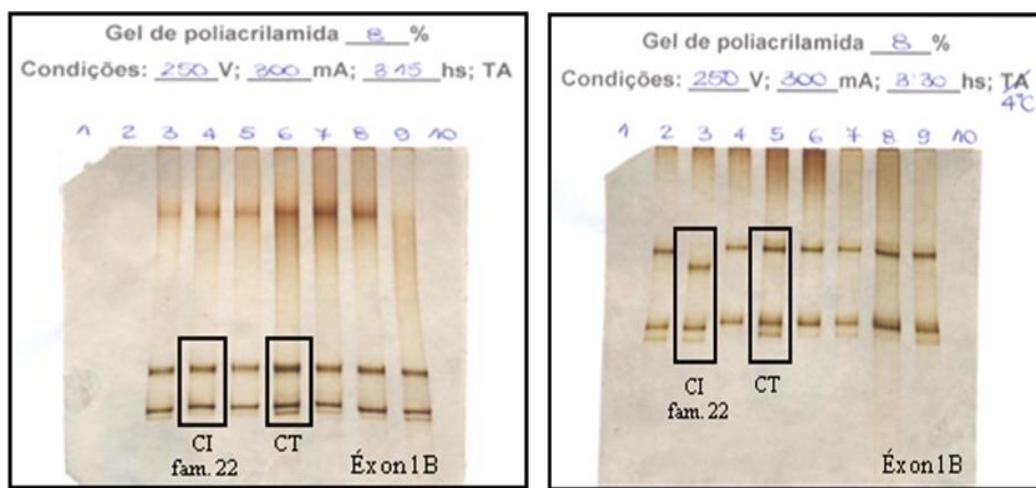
Dois géis de SSCP em duas diferentes condições de eletroforese do mesmo amplicon, demonstrando a sensibilidade quanto à temperatura. Após sequenciamento automatizado, foi identificada a mutação p.Trp137fsX57. CI = caso-índice; CT = controle.
